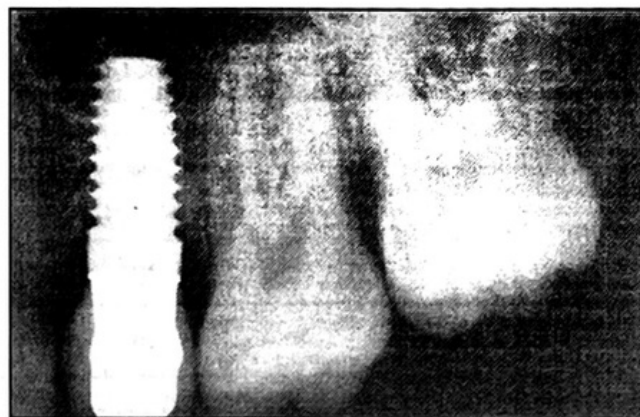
Periapical radiographs of implant #13 after 10 years of loading.
